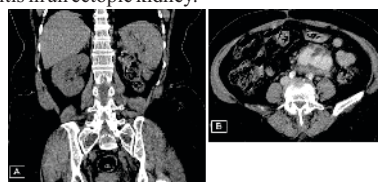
Non contrast CT abdomen in coronal reformatted format (A) shows empty left renal fossa with a normal right kidney; Contrast enhanced CT abdomen (B) in nephrogenic phase shows ectopic renal tissue in left iliac fossa with perinephric fluid collection and fat stranding.
